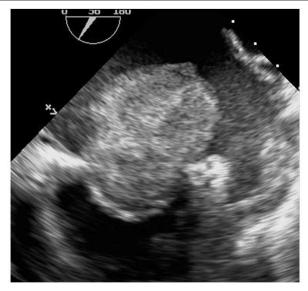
A midesophageal left atrial appendage (LAA) echocardiogram showing the Ball-Thrombus into the mitral valve orifice. It is possible to note the presence of thrombus inside de LAA.
